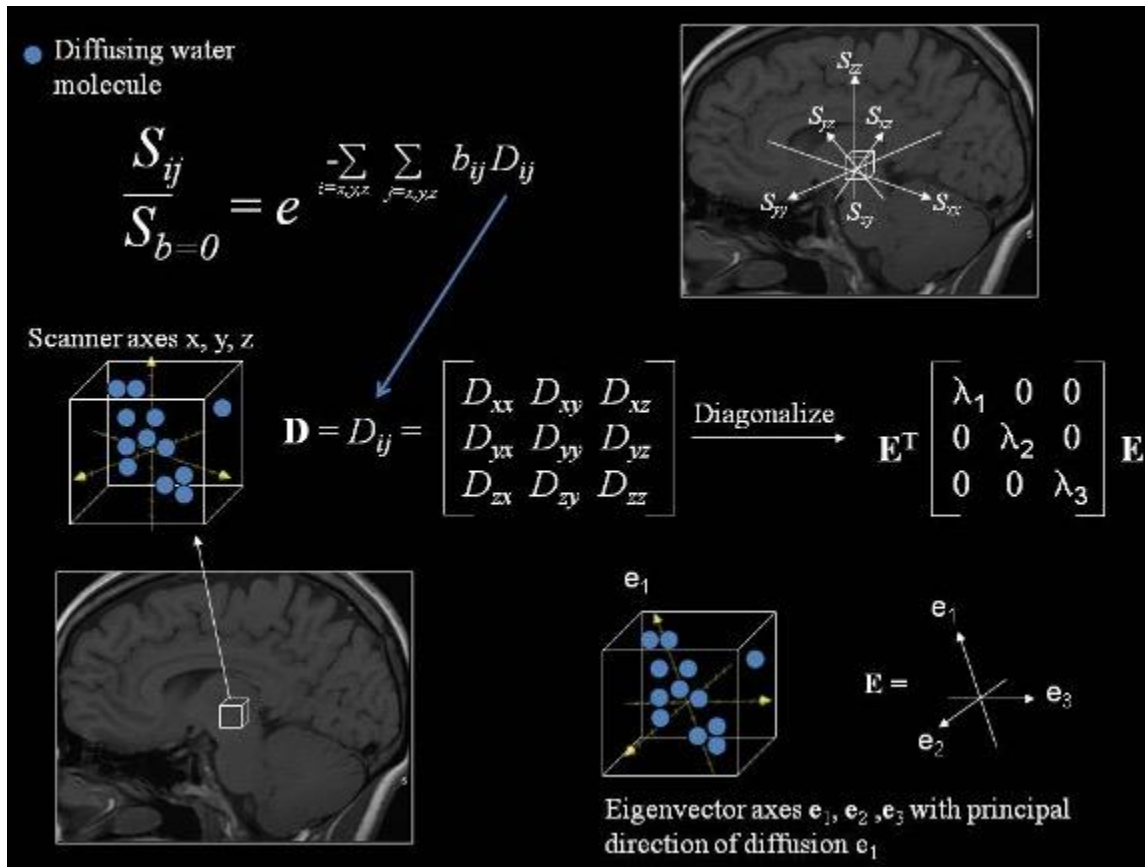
Populating the diffusion tensor. Reprinted with permission from Gallagher, T. A., Alexander, A. L., & Field, A. S. (2012). Diffusion Tensor Magnetic Resonance Imaging: Physical Principles. In S. H. Faro, F. B. Mohamed, M. Law, & J. T. Ulmer (Eds.), *Functional Neuroradiology: Principles and Clinical Applications* (pp. 709-729). Springer US.
